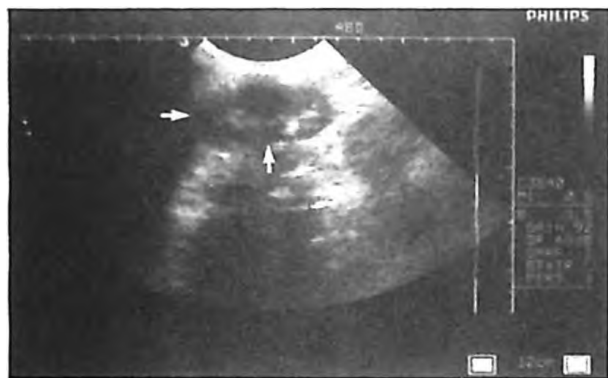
Ultrasonography of the mass in the right hemithorax through posterior thoracic wall reveals right kidney.
